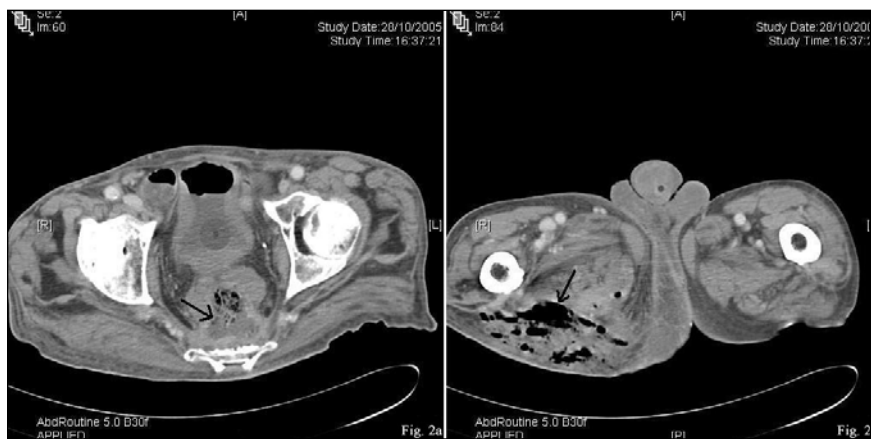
Computed tomography scan showing breakdown of posterior rectal wall and emphysema in the thigh (arrows).
